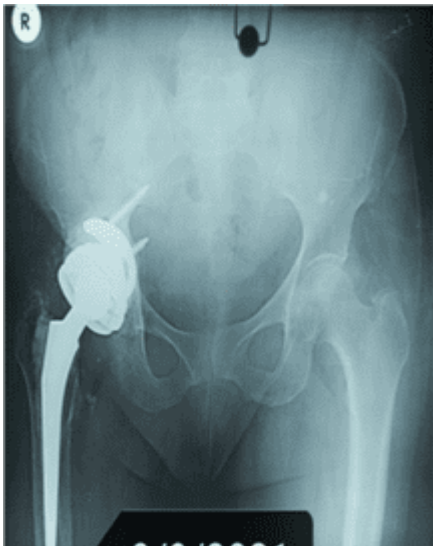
Follow up X-ray after 6 months
